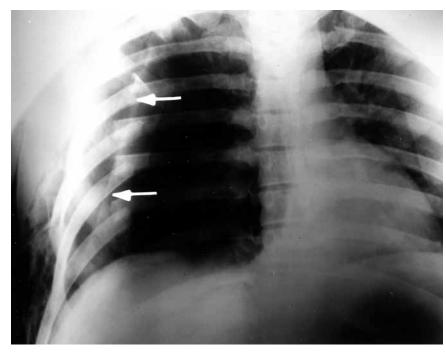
X-ray of pneumothorax. Courtesy of Leonard V. Crowley, MD, Century College.
